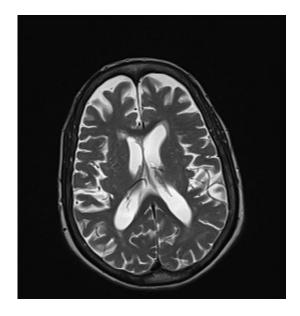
T2 TSE MRI image of the brain and temporal bones.
